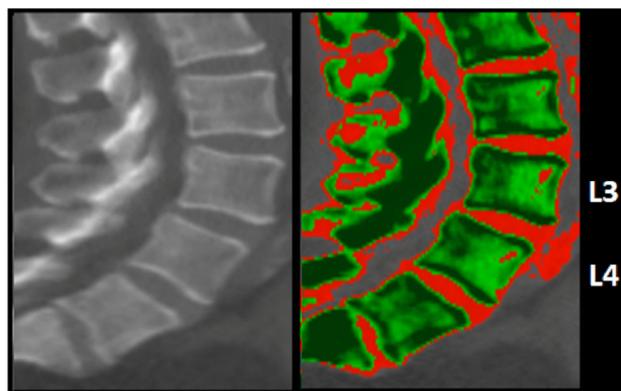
64-year-old female with normal bone density (135 mg/cm³) per QCT. Post-processed CT of the central aspect of the spine are displayed in grayscale and color, with predominantly green color in the anterior two-thirds of the trabecular portion of the L3/L4 vertebral bodies, indicating normal bone density.
